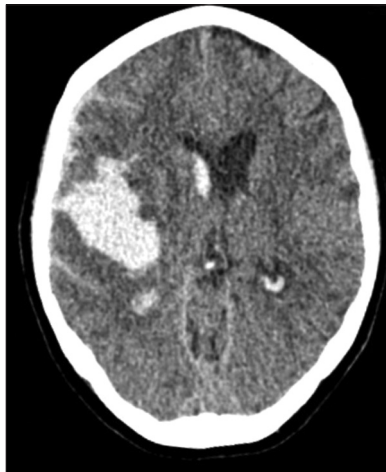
Noncontrast computed tomography of the head showing right intraparenchymal and subarachnoid hemorrhage due to aneurysm rupture of the right middle cerebral artery in patient 1.
